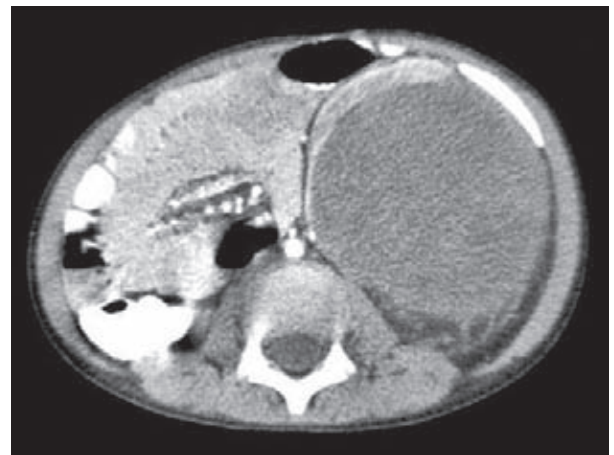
Wilms' tumour of the left kidney. Contrast-enhanced axial CT scan through the abdomen demonstrates a large mass arising from the left kidney. There is a thin rim of normal renal parenchyma around the tumour anteriorly (arrow)
